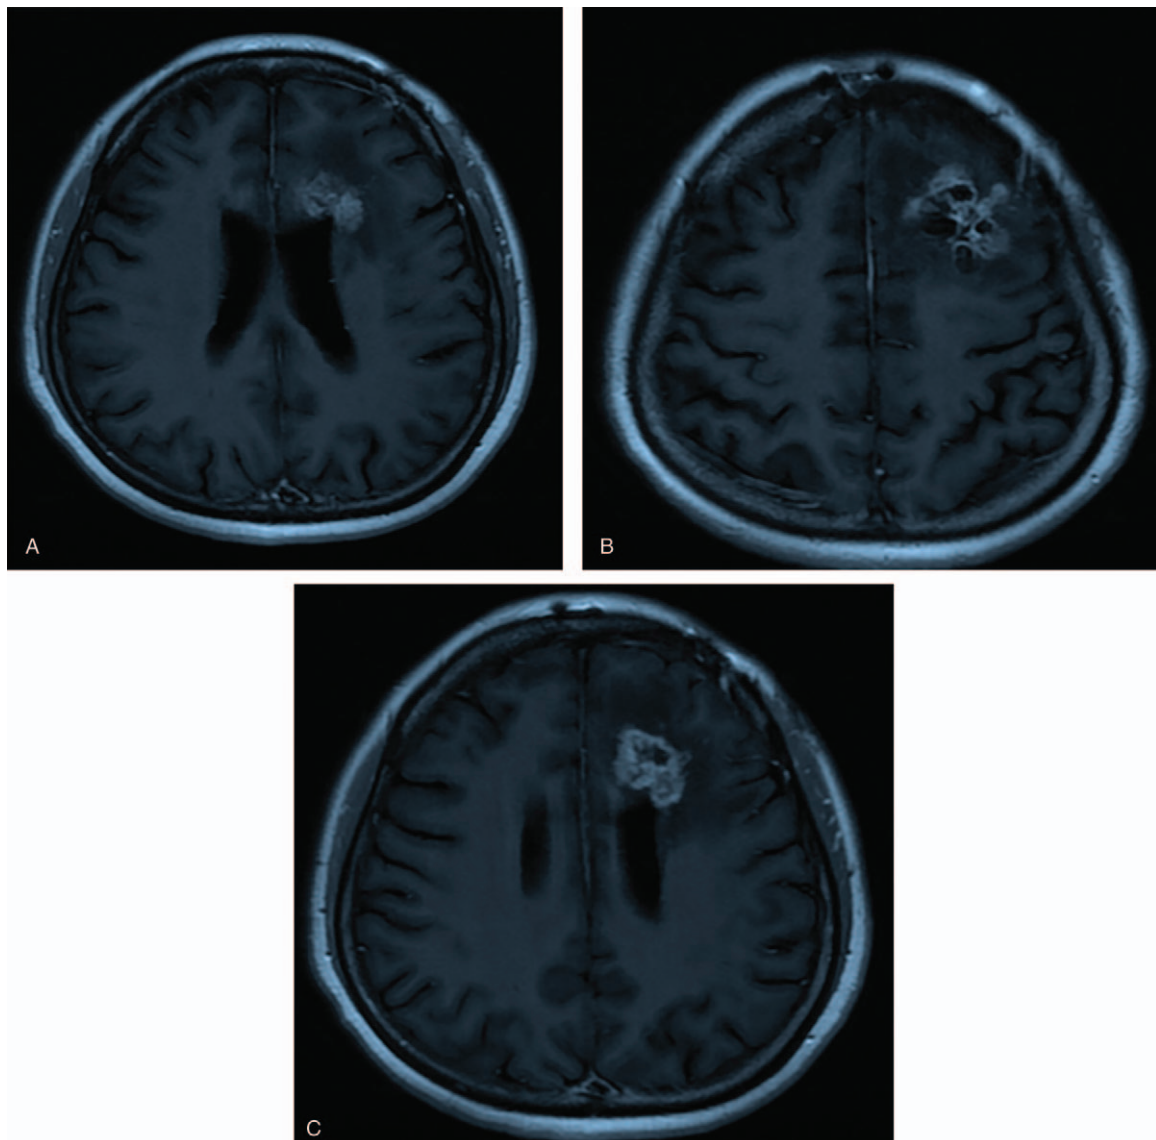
(A–C) Magnetic resonance imaging (MRI) of the patient with diagnosis of recurrence.
